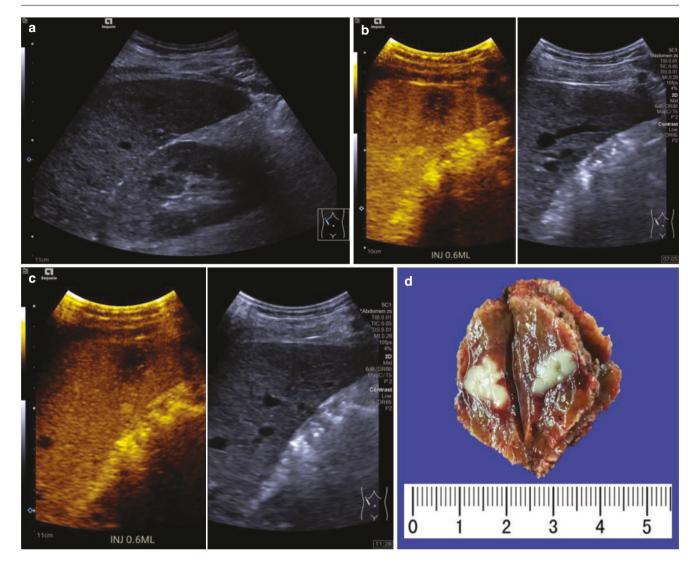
Detection of hepatocellular carcinoma (HCC) lesions that were not visualized on conventional ultrasound. A HCC lesion was suspected on right lobe of liver, while its not distinctive on B mode ultrasound (a).
